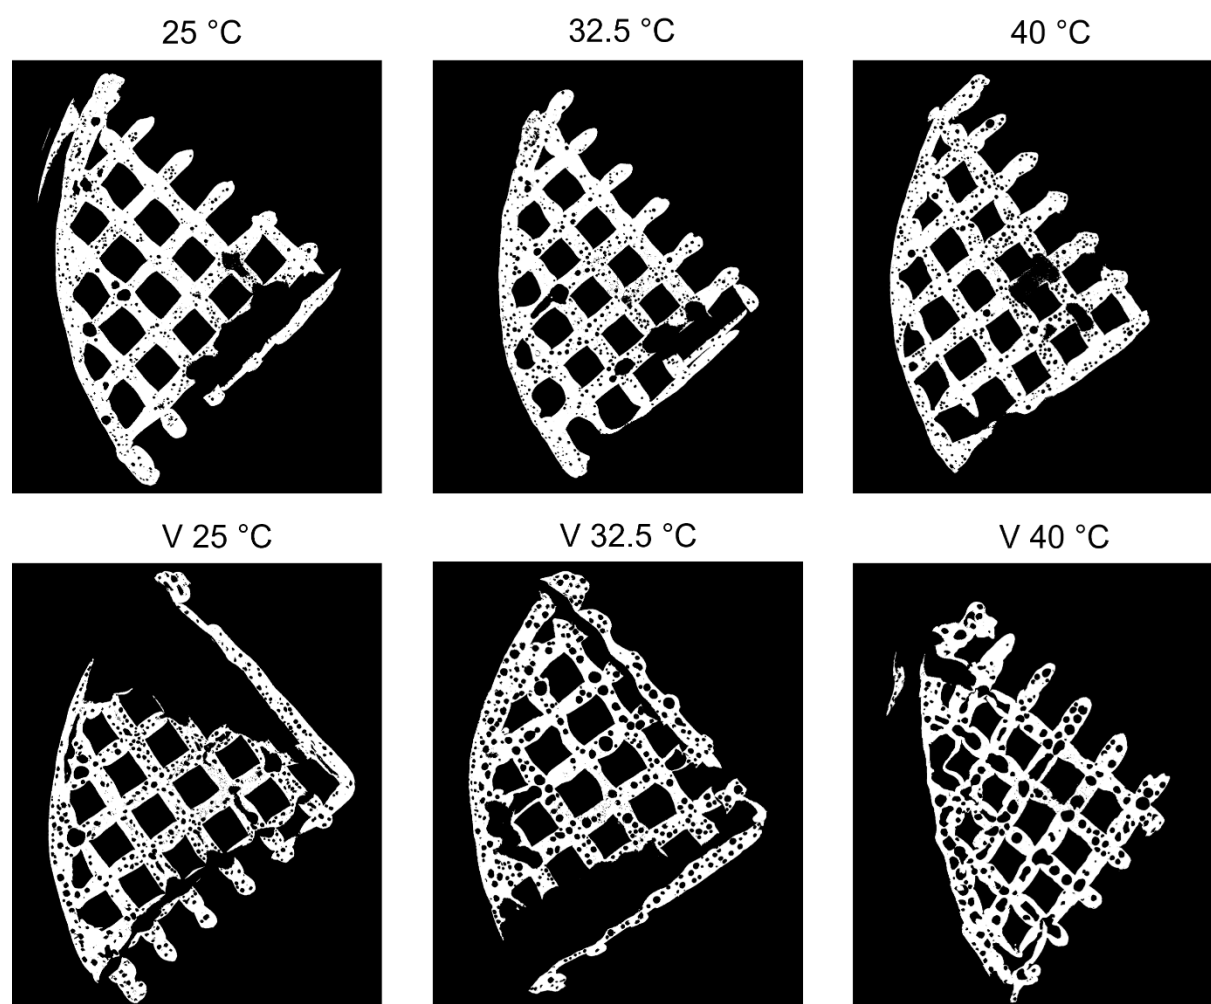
$\mu$ CT images of inserts dried at different temperatures under atmospheric (top row) and reduced (bottom row, V: vacuum) pressure.
